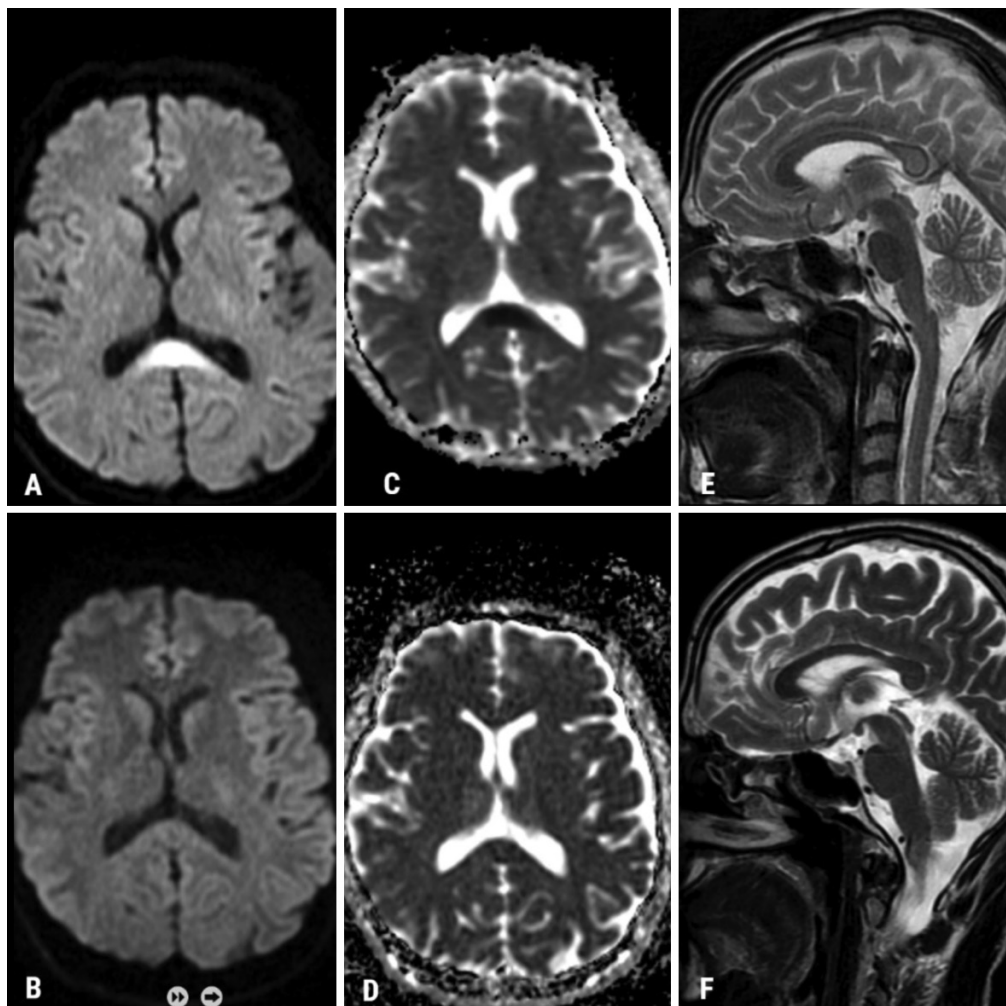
Diffusion restriction in the splenium of the corpus callosum is seen in axial diffusion-weighted images (A, C). There is also seen hyperintensity in the corpus callosum splenium in T2-weighted sagittal image (E). Follow-up magnetic resonance imaging performed approximately one month later shows that all findings were completely disappeared (B, D, F)
